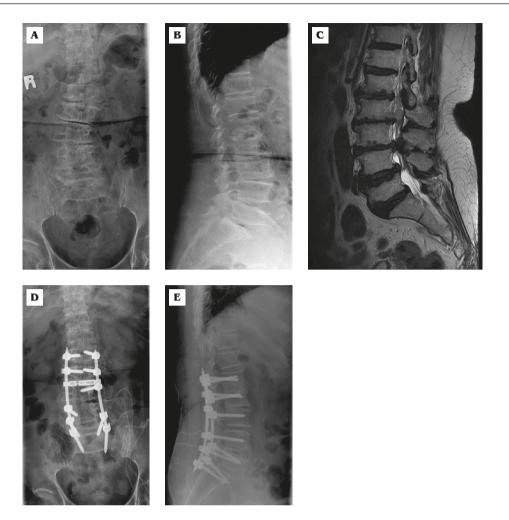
A 66-year-old woman with L1–S1 degenerative scoliosis and instability. Preoperative and postoperative images show: (A) the lumbar spine in an anteroposterior view; (B) the lumbar spine in a lateral view. (C) T2-weighted magnetic resonance imaging. (D) Postoperative lumbar spine anteroposterior view. (E) Postoperative lumbar spine lateral view.
